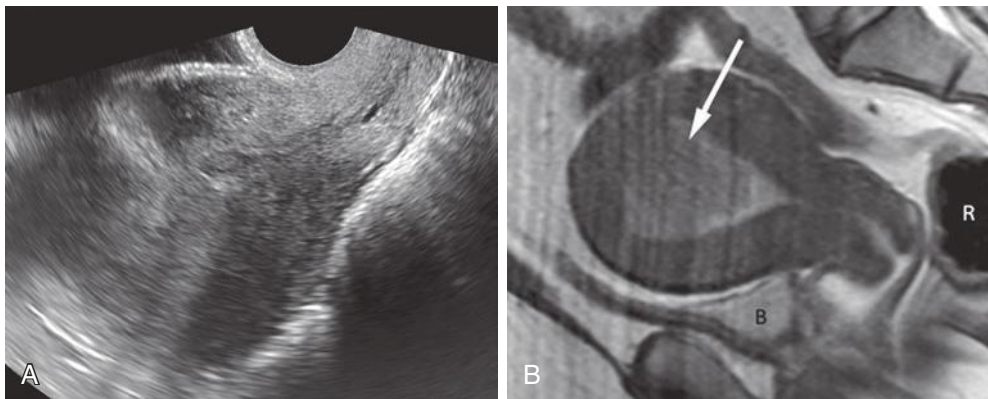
A 43-year-old premenopausal nulliparous woman with history of endometrial hyperplasia, obesity, and hypertension now with abnormal bleeding. A, Longitudinal transvaginal sonographic image of the uterus demonstrates a poorly visualized endometrial stripe. It could not be determined if this was due to technical factors or true endometrial disease, and therefore, a magnetic resonance imaging scan was performed. B, Sagittal T2-weighted image of the uterus shows a polypoid endometrial mass (*arrow*), hypointense relative to the normal high signal intensity endometrium. The mass-myometrial interface at the uterine fundus is ill defined, concerning for invasion; however, this is less than 50% of the myometrial thickness. Stage 1A endometrial cancer was confirmed at hysterectomy. B, bladder; R, rectum.
